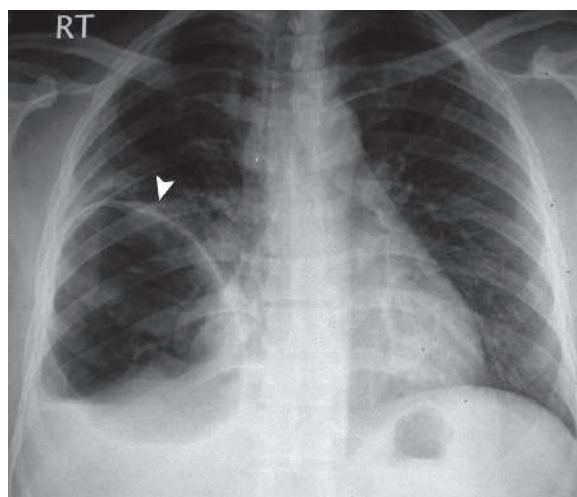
Posteroanterior plain chest radiograph shows large right lower zone bulla (*arrowhead*)
